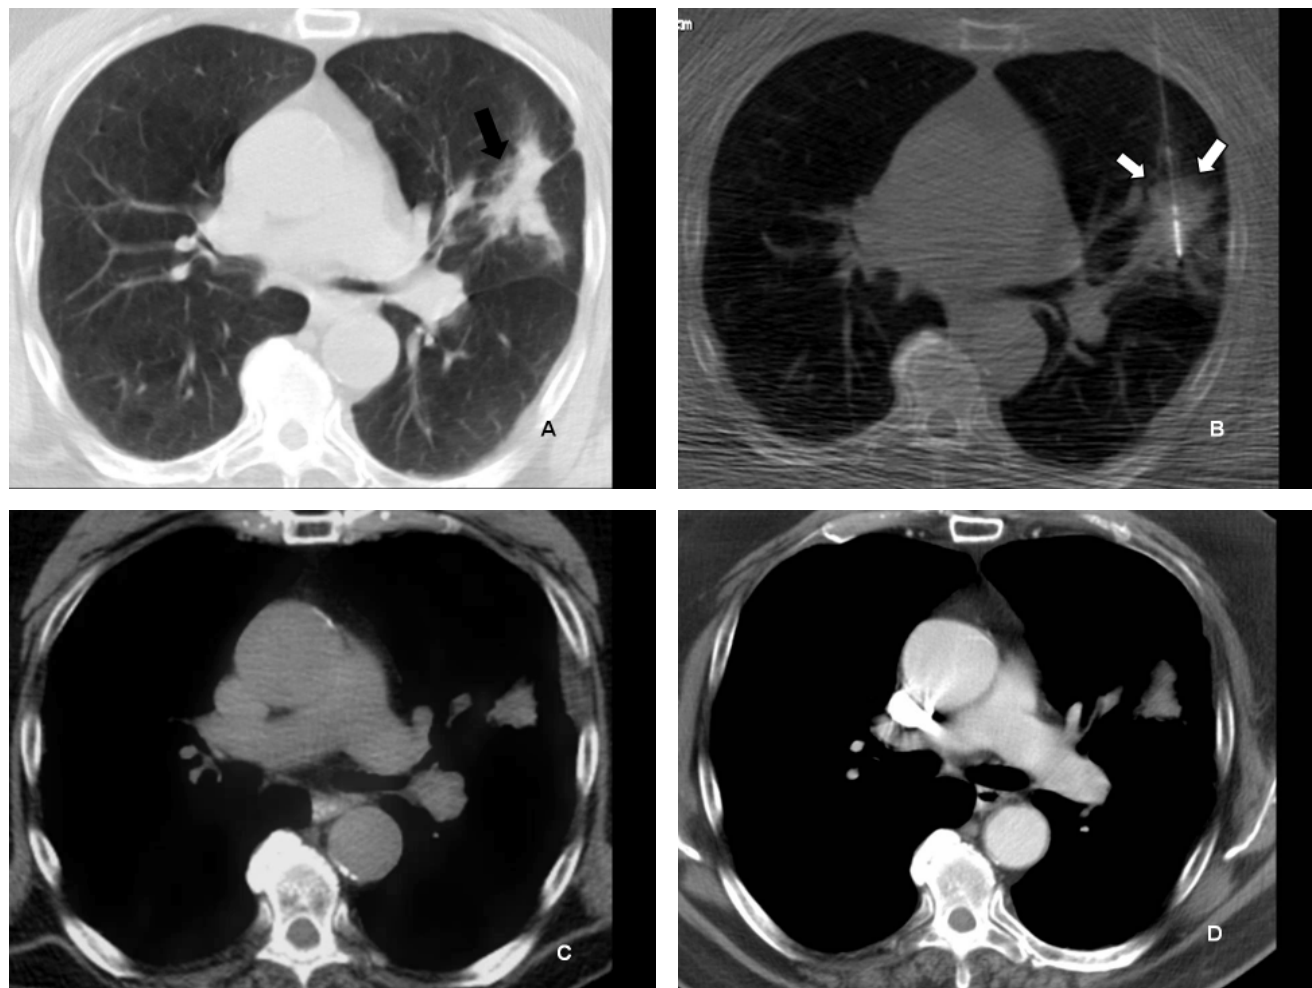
A 78 year old male presented with a 5cm, stage 1B, left upper lobe (LUL) adenocarcinoma (upper left, black arrow) and underwent RFA with a deployable tine electrode visualized intraprocedurally (upper right, white arrows indicate 2 tines). Follow-up PET-CT (lower left) 8 months post-ablation shows thermal scarring at the ablation site within the LUL with no uptake. One-year follow-up chest CT (lower right) also shows no signs of residual nor recurrent disease at the LUL ablation site.
